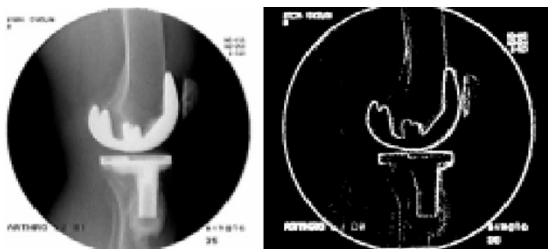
Input X-ray image, inverted (left) and gradient image (right).
